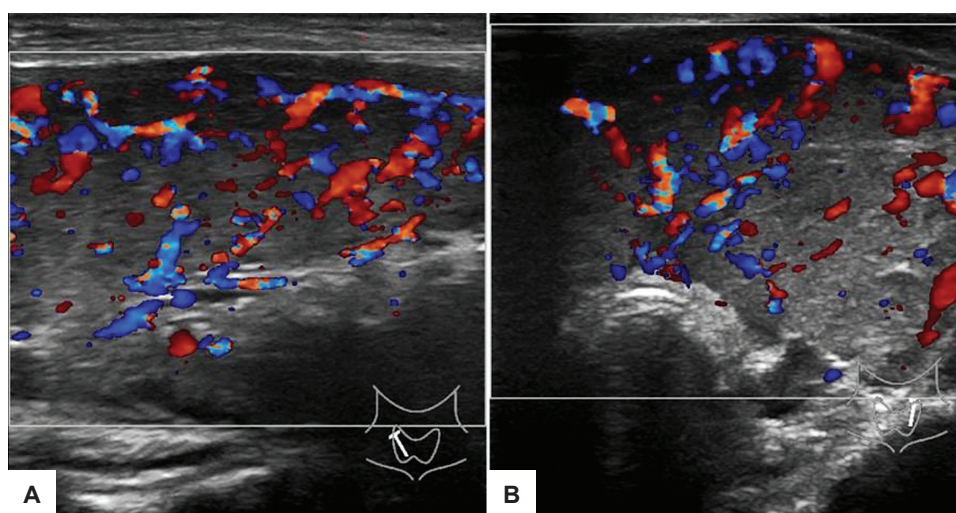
Ultrasound color Doppler thyroid gland showing heterogenous echogenicity and increased thyroid vascularity of right (A) and left (B) lobes.
